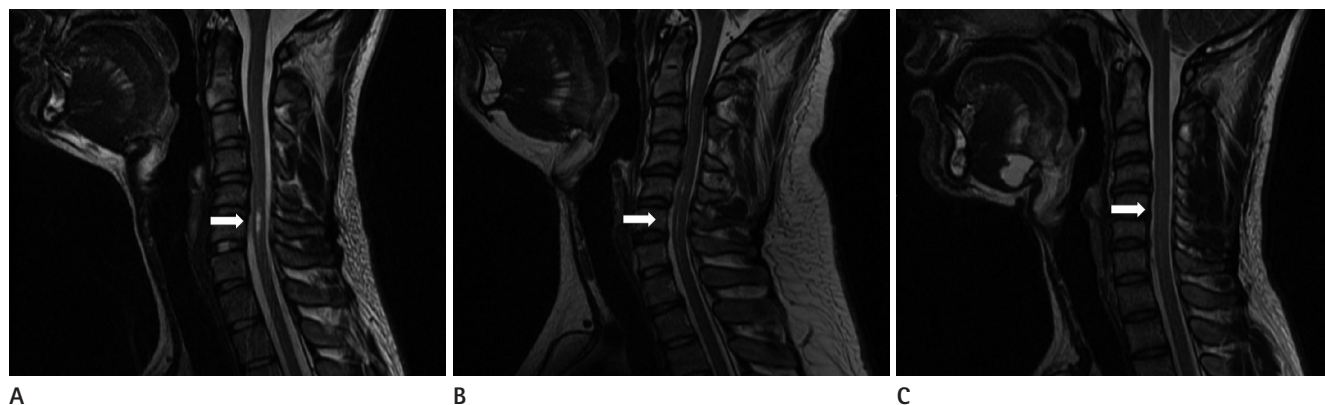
Three cases of syringomyelia check by C spine regional magnetic resonance (MR). Syringomyelia is a well demarcated cavity (arrows) with an increase signal on a T2 weighted image on a MR image within the spinal cord in the level of C6 (A), C5-6 (B), and C3-6 (C).
